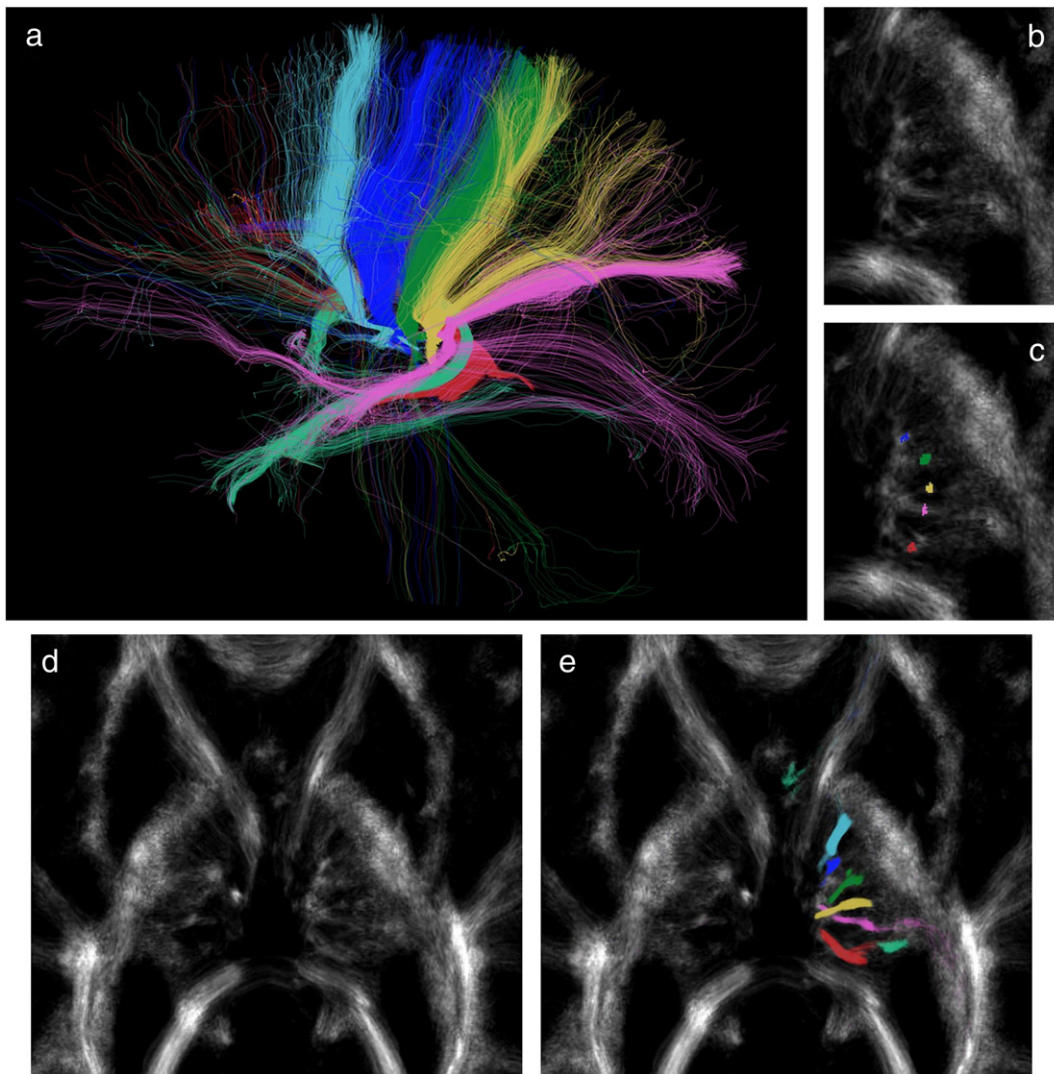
Targeted fiber-tracking for seeds defined in the thalamus. (a) Targeted fiber-tracking resulting from 7 small seed ROIs. The tracks are shown on a sagittal projection (left side of image is anterior anatomically), and the tracks generated from each seed ROI are labeled with different colors. The seed ROIs were defined in areas identified in the high-contrast TDI maps (maps generated with 250 μm isotropic resolution using 1,000,000 tracks); see (b) for an example axial slice (zoomed at the level of the thalamus), and (c) for 5 of the 7 seed ROIs present in that slice (the remaining 2 seed ROIs were defined in different slices). (d) Zoomed-region on a different axial slice at the level of the thalamus, and (e) the corresponding fiber-tracking results (only the tracks within the 250 μm -slice are displayed). The color-coding used in (c) and (e) corresponds to the same convention used in (a). Note that the fiber-tracking results are generated from the original (low resolution) DWI data, and the TDI maps are only used to define the seed ROIs.
